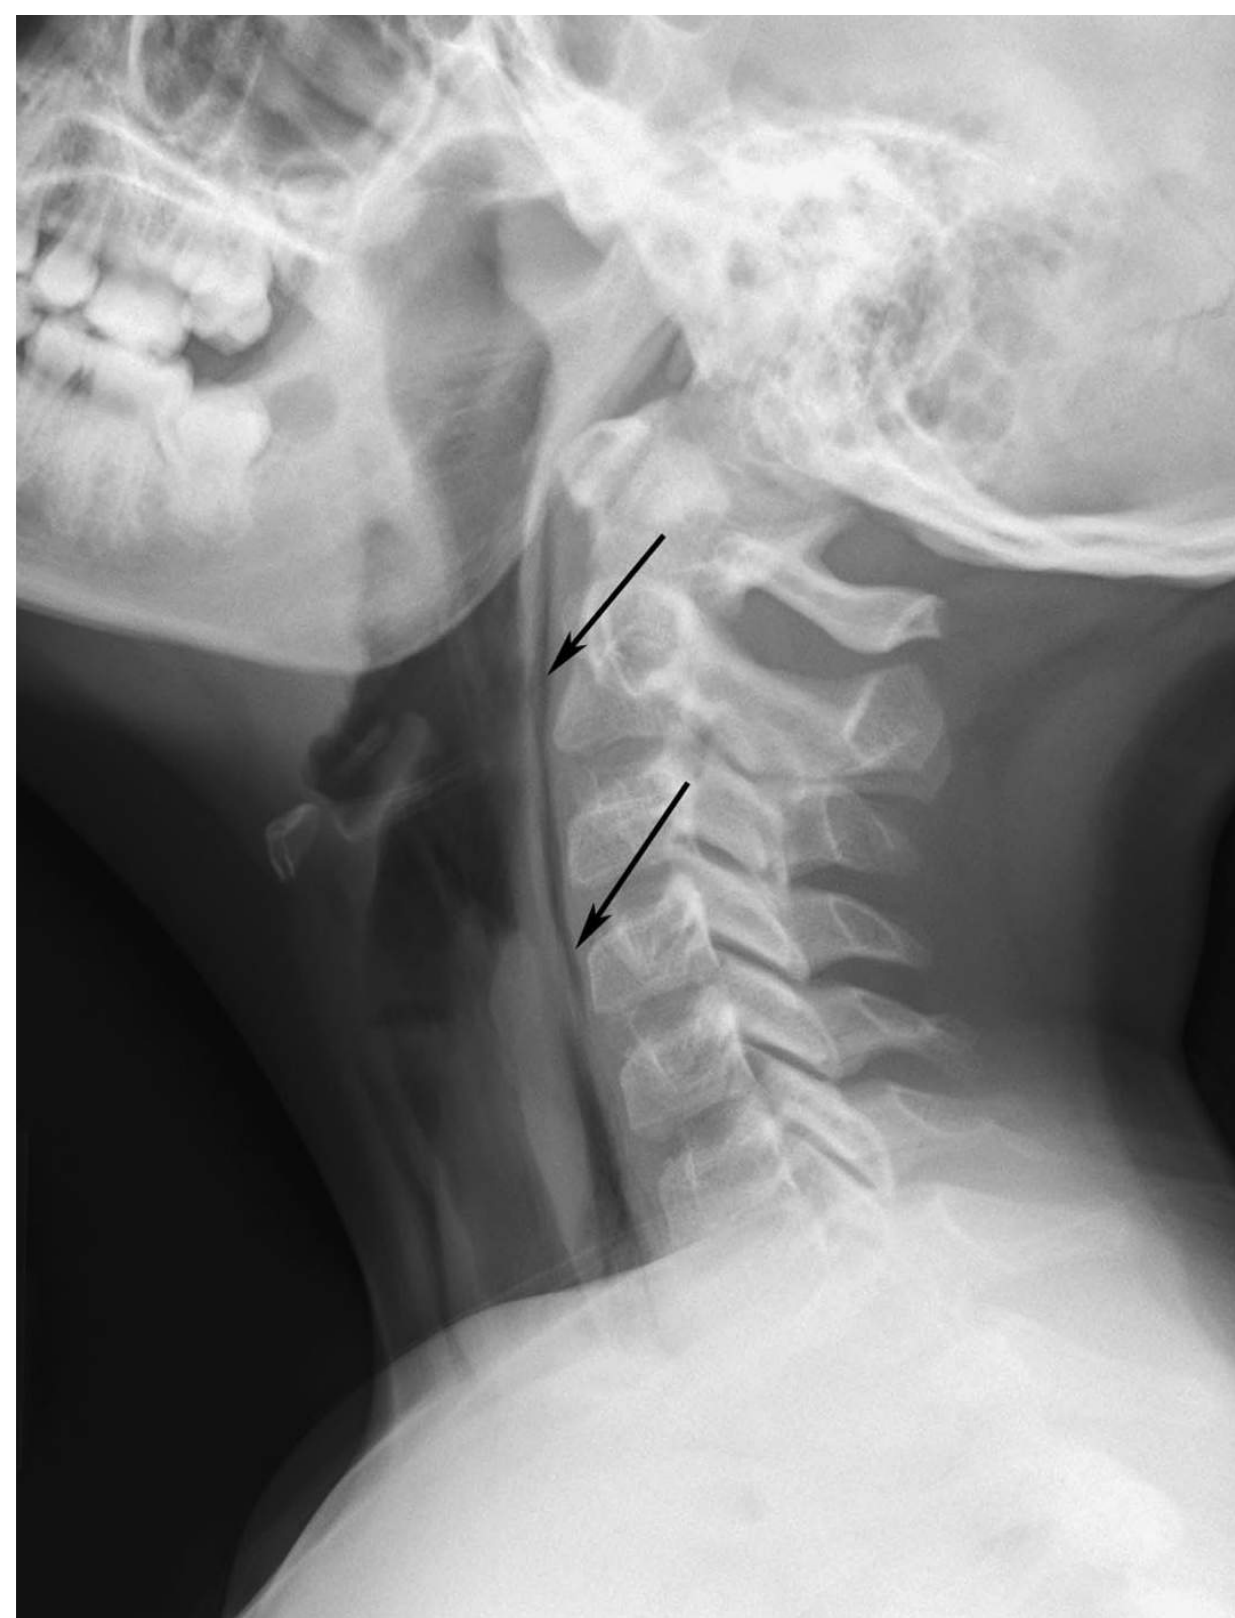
■ Oropharyngeal Injury. Fingers, utensils, or other objects can perforate the oropharynx when shoved into the mouth of young children in the course of feeding or in an attempt to pacify an infant. This should trigger a thorough evaluation for other abusive injuries. This x-ray demonstrates retropharyngeal air (arrows) indicating oropharyngeal perforation. (Photo contributor: Marguerite Care, MD.)
